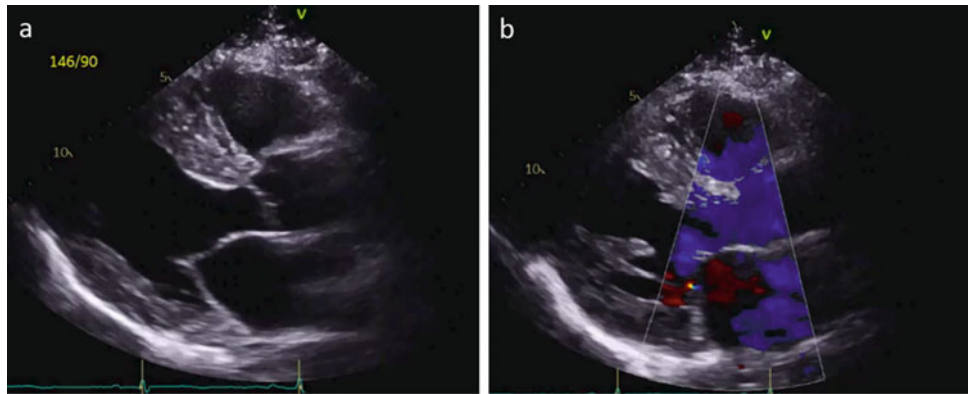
a Parasternal long-axis view showing asymmetric septal hypertrophy with IVS = 1.6 cm; LVIDd 5.0 cm; PW 1.2 cm; LV mass 139 gm/2. No evidence of systolic anterior motion of the mitral valve. b Color Doppler shows no evidence of turbulent flow across the outflow trace and no mitral regurgitation. IVS = interventricular septal thickness; LVIDd = left ventricular internal dimension in diastole; PW = posterior wall
